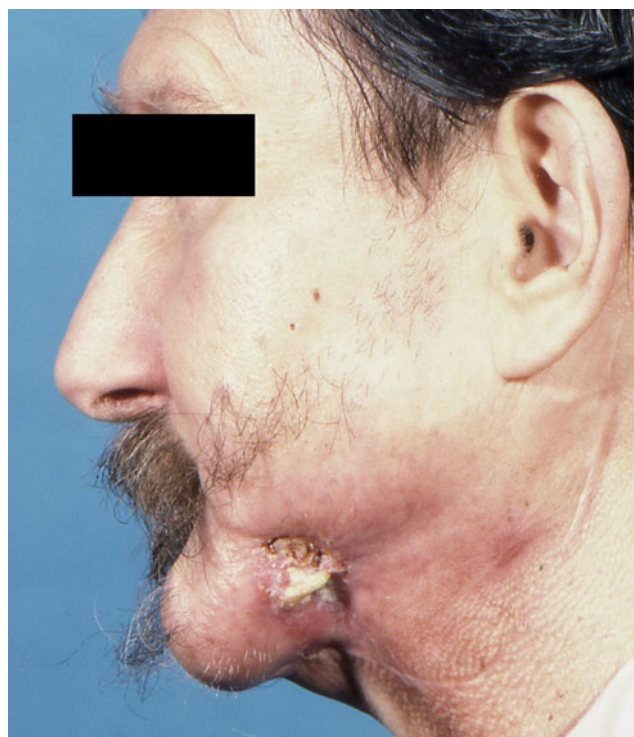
Treatment of osteoradionecrosis with shortwave ultrasound (before ultrasound)
